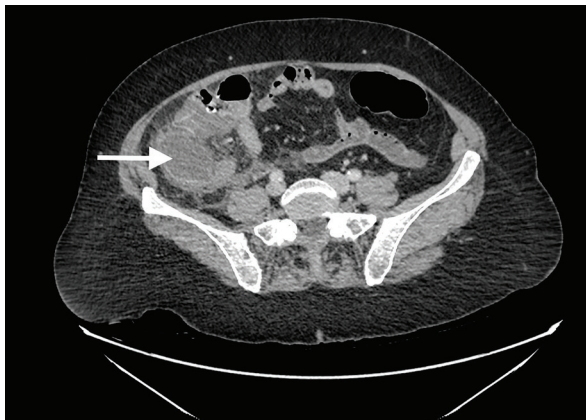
Axial computed tomography demonstrates a dilated, tubular, fluid-filled structure in continuity with the caecal pole, in keeping with an appendix mucocoele.
